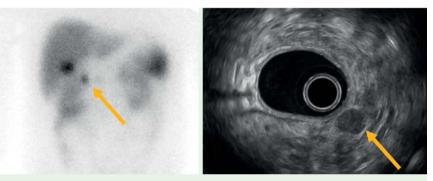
Preoperative images of the peripancreatic lymph node gastrinoma as visualized by a somatostatin receptor scintigraphy and b endoscopic ultrasound.
